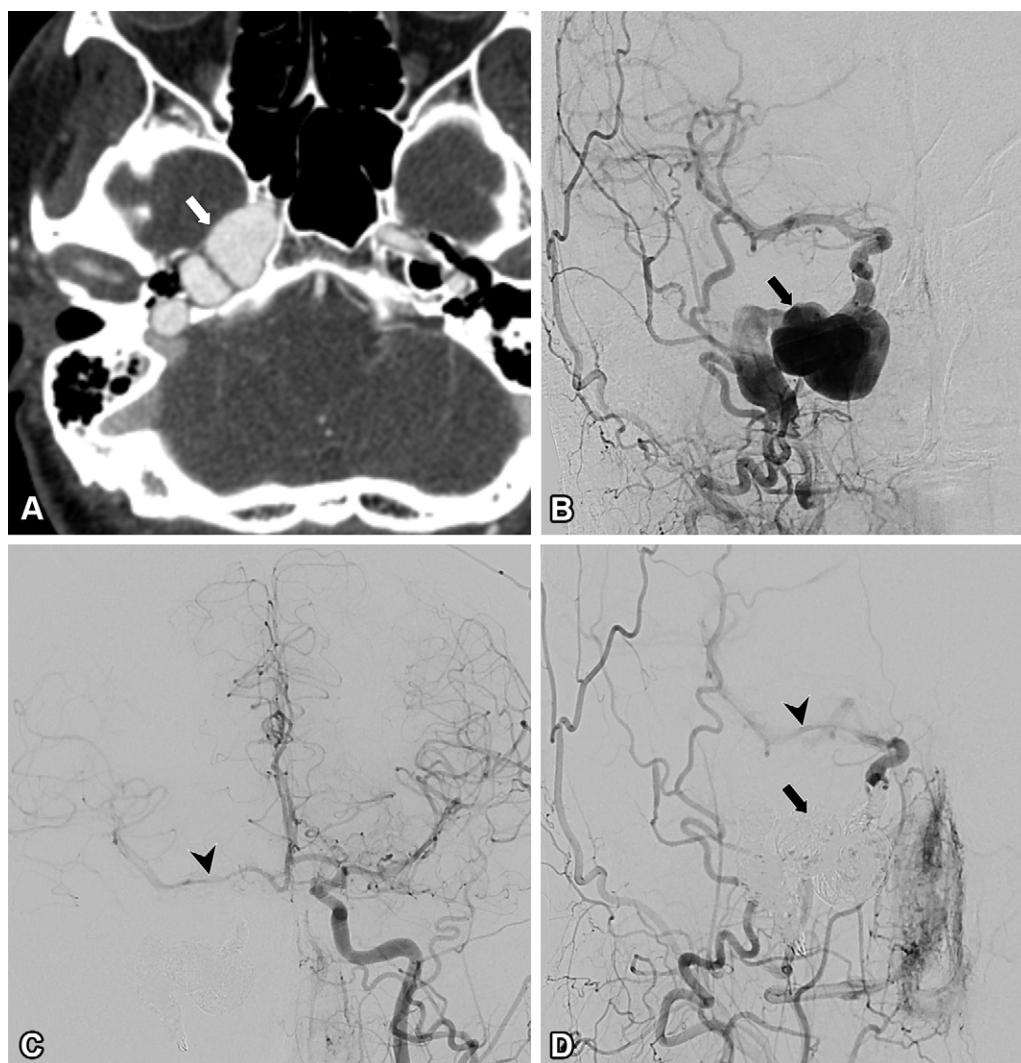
Left petrous ICA aneurysm in a 33-year-old woman with a 3-month history of progressive constant right pulsatile tinnitus. (A) Axial CT angiogram through the horizontal petrous segment of the right ICA shows a large petrous aneurysm (arrow). This eroded into the middle ear cavity, pneumatized petrous apex, and mastoid air cells (not shown). (B) Initial frontal DSA image obtained with right common carotid artery injection shows the petrous aneurysm (arrow). (C) Angiogram after coil embolization of the aneurysm shows some filling of the right middle cerebral artery (arrowhead). (D) DSA image obtained with left common carotid artery injection after coil embolization of the aneurysm (arrow) shows collateral filling of the right anterior and middle cerebral arteries (arrowhead). The patient's pulsatile tinnitus resolved after embolization of the right ICA.
